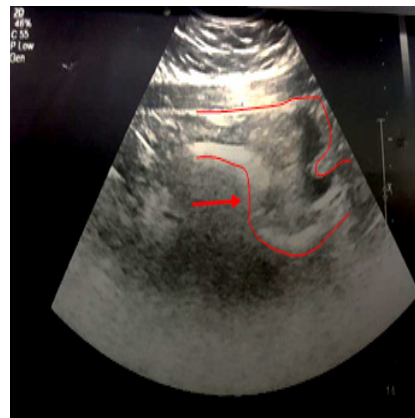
The ultrasound image showing an increase in the thickness of the cecum, and ascending and transverse colon
